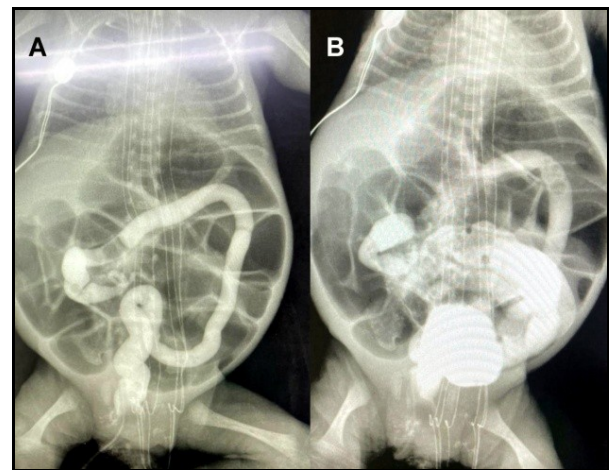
Radiographs in MIOFI showing severe intestinal distention without air-fluid levels. (A) Gastrografin™ enema showing microcolon, (B) Contrast refluxes into the ileum proximal to the obstruction (Patient 1)
